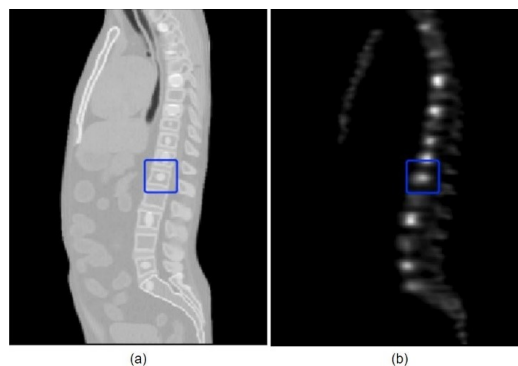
Images (a) and (b) contain an example sagittal slice of 3D ROI selection in the CT (left) and the SPECT (right) images.
